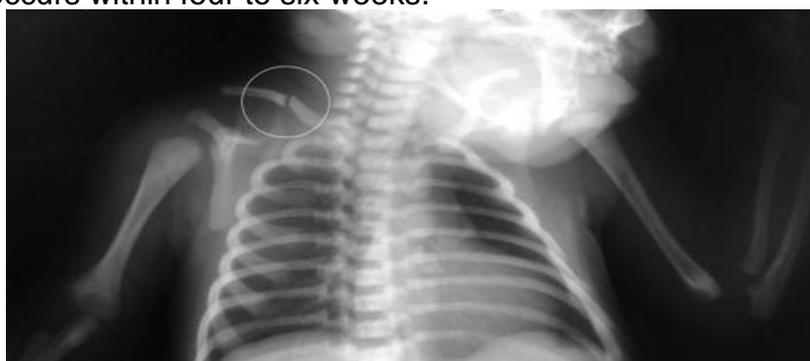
Antero-posterior radiograph of a nondisplaced mid-shaft clavicle fracture in children
